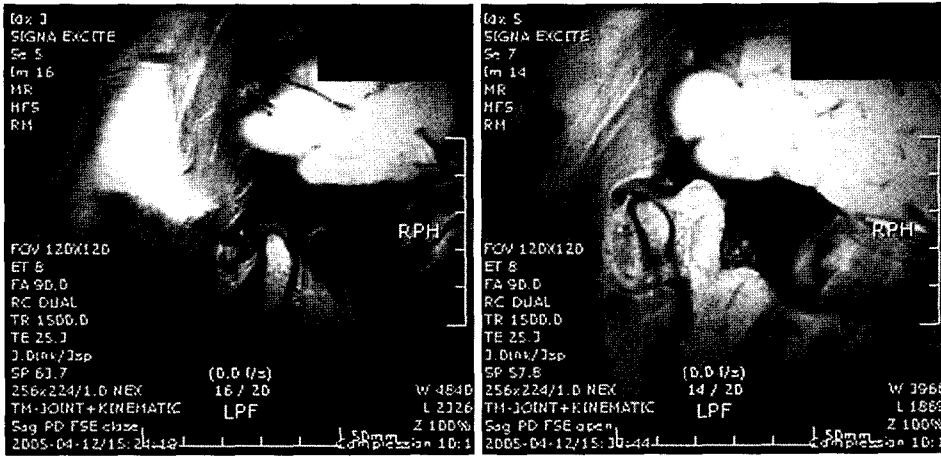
The static MRI of TMJ ID without reduction.
